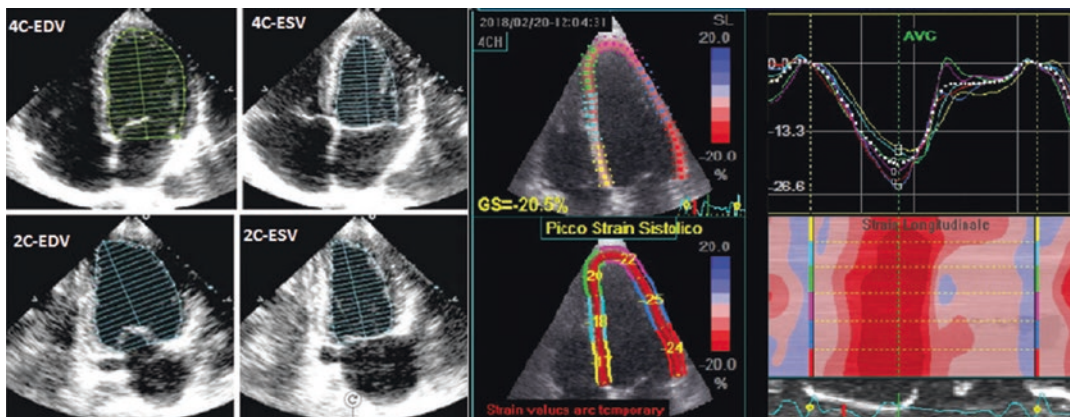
Left panel: Simpson's biplane method. Right panel: speckle-tracking echocardiography (STE)
